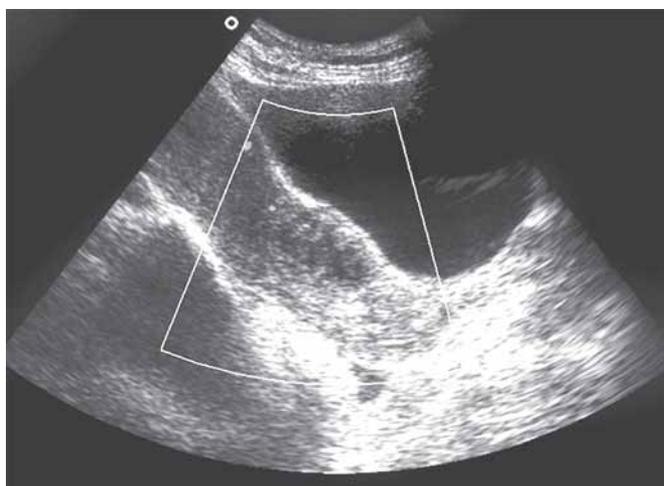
Transvaginal sonography after 1 week of D&E, showing hypoechoic lesion with hydropic changes of 2.2 × 1.4 cm in the lower part of uterus invading anterior wall at the LSCS scar site
